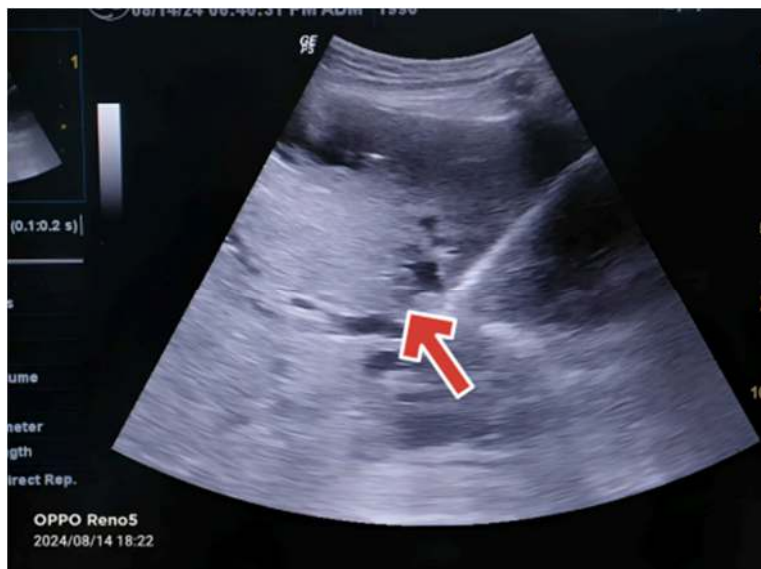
Mass in the Liver on Ultrasound Abdomen
